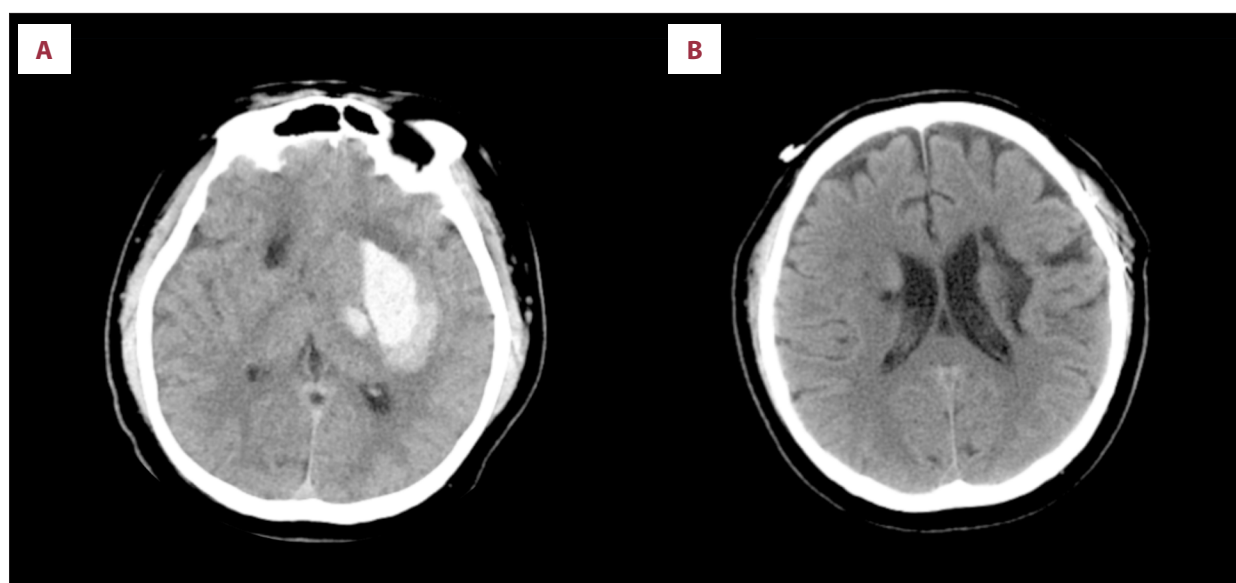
Head CT findings. (A) Pre-admission CT scan showing intracerebral hemorrhage in the left basal ganglia region and subarachnoid hemorrhage. (B) Follow-up CT scan after admission, demonstrating postoperative changes following left basal ganglia intracerebral hemorrhage evacuation, with evidence of encephalomalacia formation in the surgical area. CT, computed tomography.
